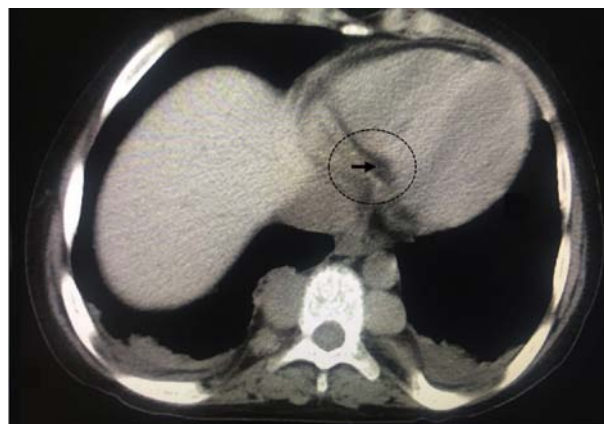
A scan of a 58-year-old male patient with leukemia presenting with a homogeneous mass (arrow) on the left side using chest computed tomography (mediastinal window; an axial view of the chest with emphasis on the mediastinum).
